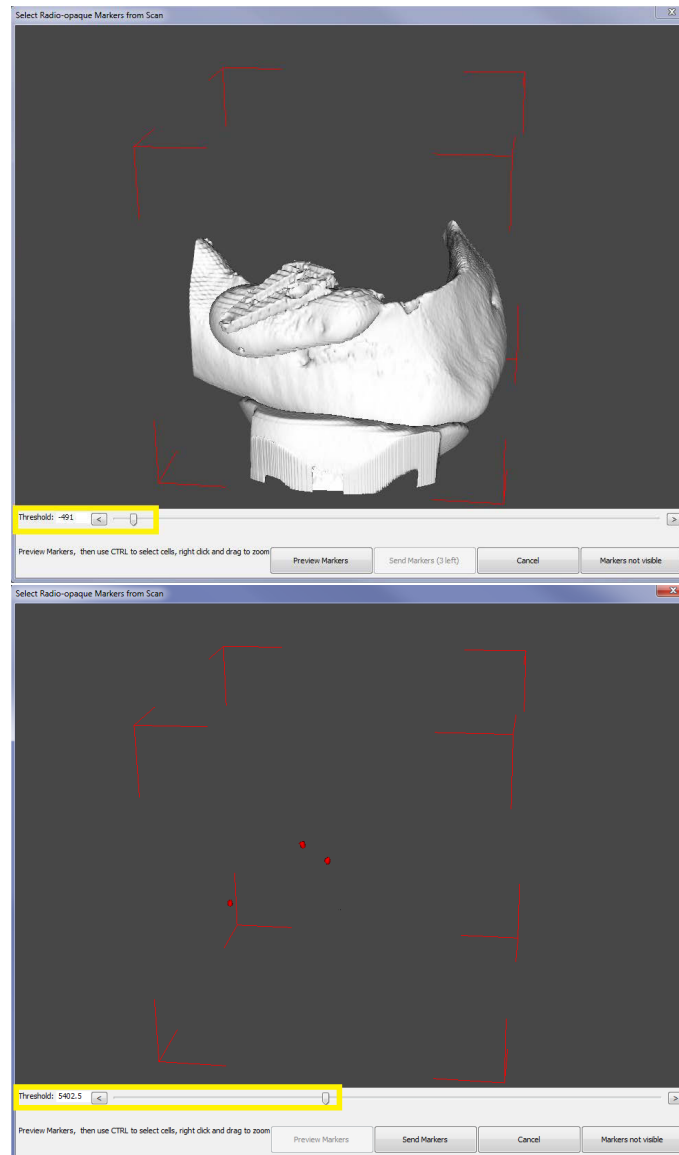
Digital extraction of fiducial markers (top) from segmenting the isosurface of the radiographic template (bottom) at different threshold values.
